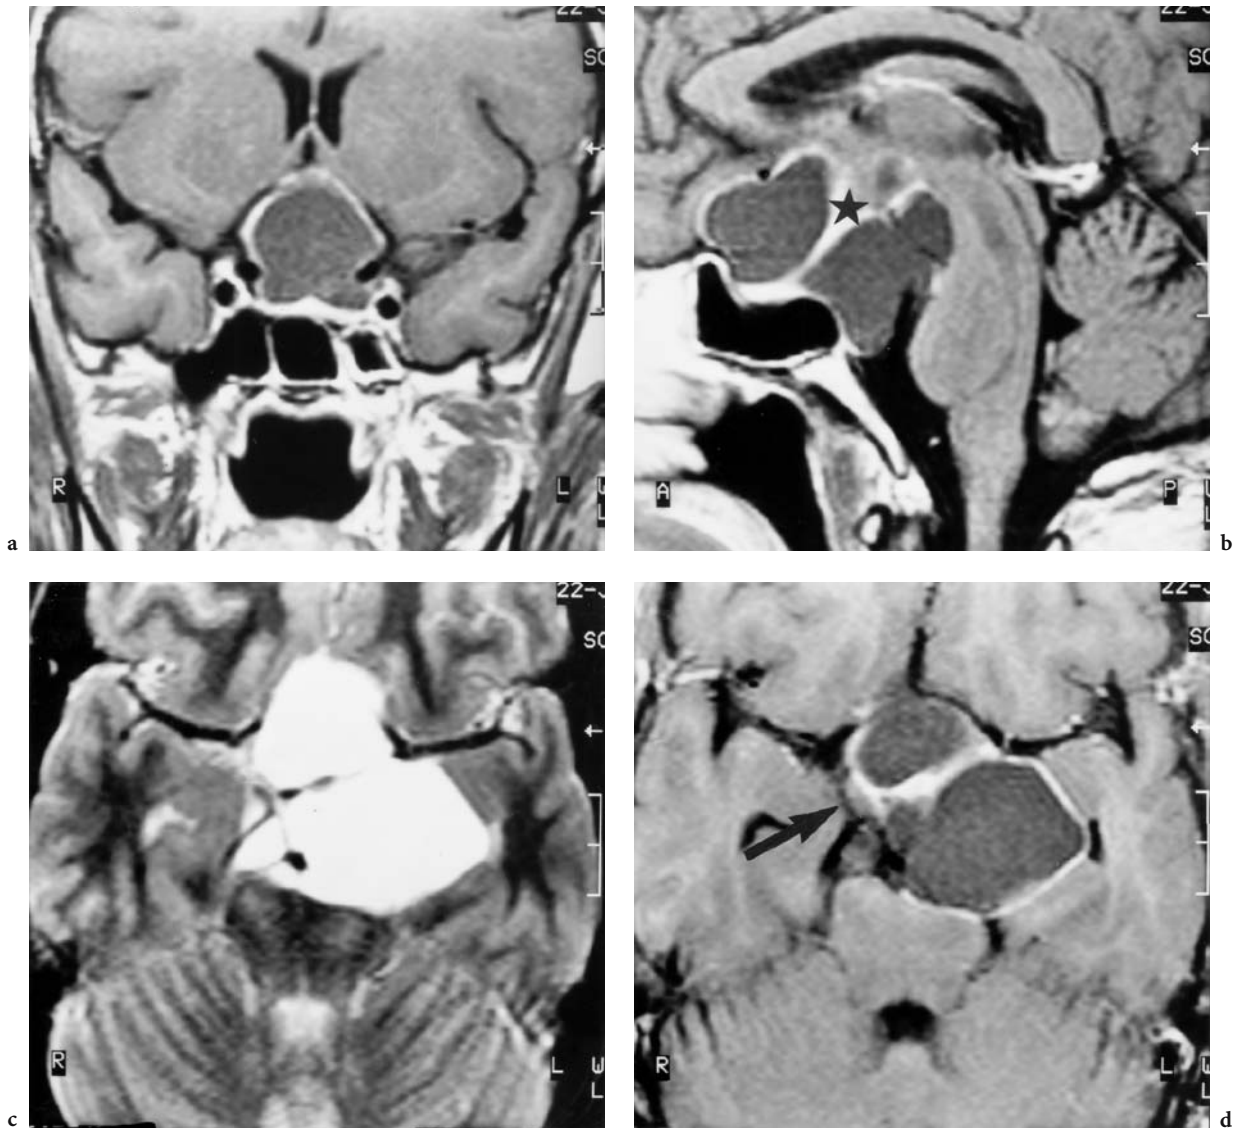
A 36-year-old man with visual deficit (finger counting) of the right eye, detected during routine control. Diagnosis: craniopharyngioma. MRI: a Coronal, T1-weighted, contrast-enhanced image with caudal depression of the third ventricle by the predominantly suprasellar, cystic tumor. The contrast-enhanced capsule is visualized, while the chiasm is not seen. b Midsagittal view with differentiation of the pituitary stalk (*star*). Note the depression, dislocation, and deformation of the brainstem. c Axial T2-weighted image demonstrating the high proton content (high signal) of the oily fluid content of the cystic tumor region. Note the deformed brainstem. d Corresponding T1-weighted, contrast-enhanced image where a remnant of the chiasm (confirmed on operation) is seen at the medial right tumor surface (*arrow*). (From MÜLLER-FORELL and LIEB 1995)
